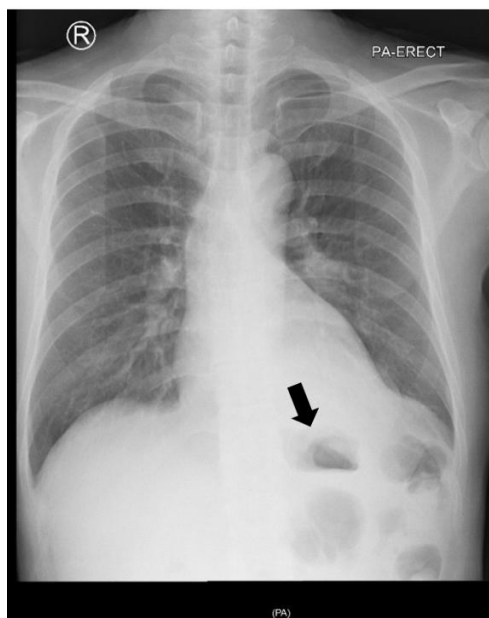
Chest X-ray shows left diaphragmatic hernia (black arrow).
